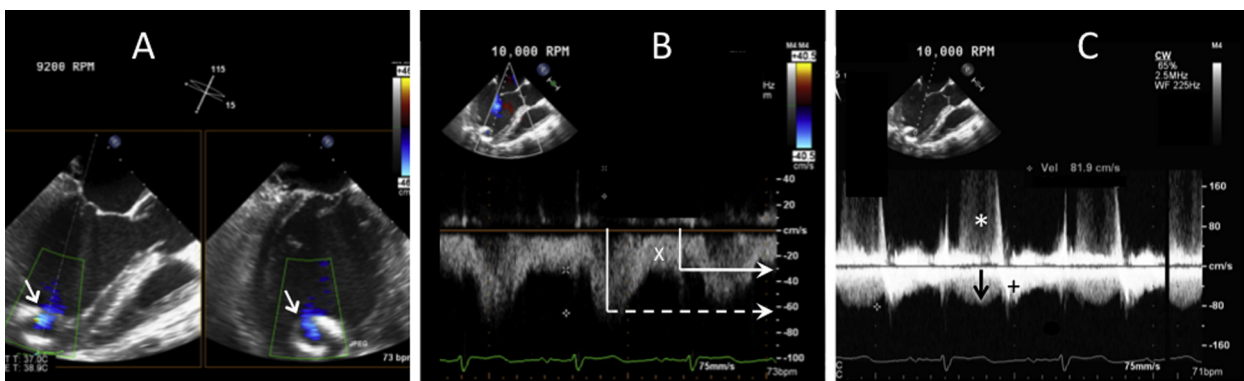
(A) After LVAD implantation, TEE shows that the inflow cannula is somewhat directed towards the ventricular septum (arrow). This can be acceptable but may predispose to inflow-cannula obstruction after sternal closure or later reduction in LV size. However, cannula position and flow velocities are shown to be acceptable (normal) in this case. Simultaneous orthogonal plane imaging reveals unobstructed, laminar inflow-cannula flow on 2D and color-flow Doppler (blue) examination. See also Video 5. (B) Pulsed Doppler interrogation of the inflow cannula shows a typical continuous, systolic dominant inflow pattern. Dashed arrow = peak systolic velocity; X = nadir diastolic velocity. (C) Continuous-wave spectral Doppler interrogation of the inflow cannula (to screen for inflow obstruction) shows normal inflow-cannula systolic flow (black arrow); “+” indicates a hybrid signal that results from overlapping of continuous diastolic inflow-cannula flow and diastolic MV inflow; “”) indicates MR velocity.
